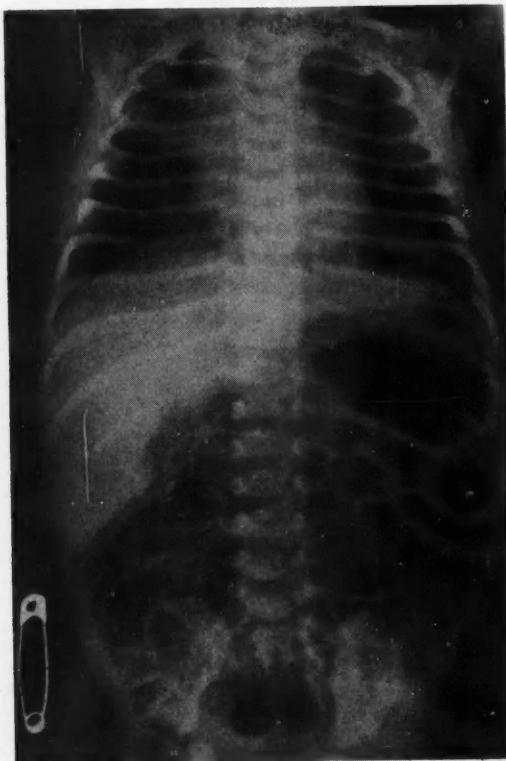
Case 1.—Air within the upper intestinal tract is noted. In a newborn with a blind upper esophageal segment, air could be present thus only if an air passage communication existed. In Case 2 a similar roentgenogram was nearly identical.
